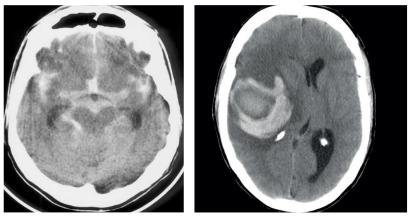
Plain axial CT brain; RT SAH, LT MCA Intracerebral hemorrhage.Elshargawy2014
